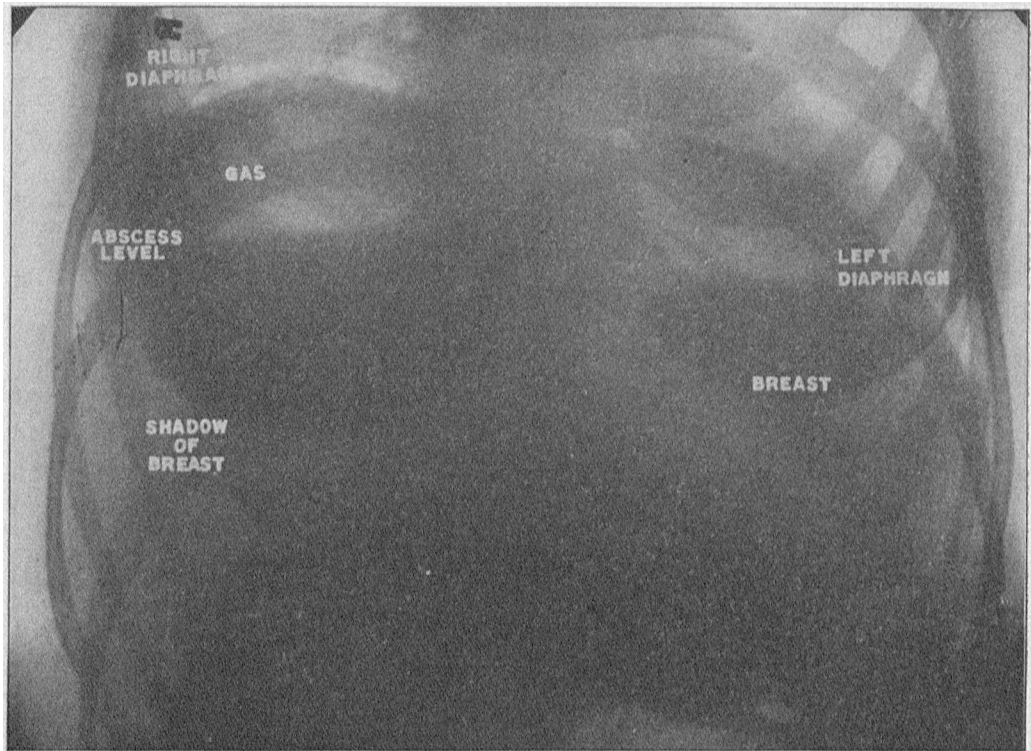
X-ray of CASE 3, in sitting position. Note persistent high diaphragm on right; straight line level of the pus in the abscess with gas above it. (X-ray with portable machine by Dr. Frank Wheatley.)
